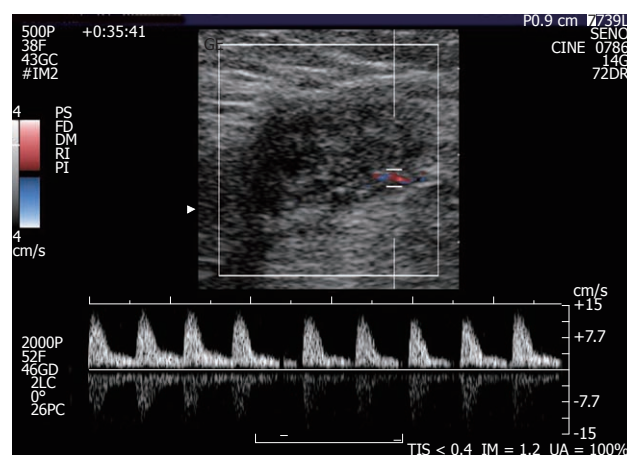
A small endometrioma with the typical single vascular pedicle entering the mass at the periphery. No central vascularisation is observed. Doppler demonstrates high resistance arterial flow (resistive index > 0.7).
